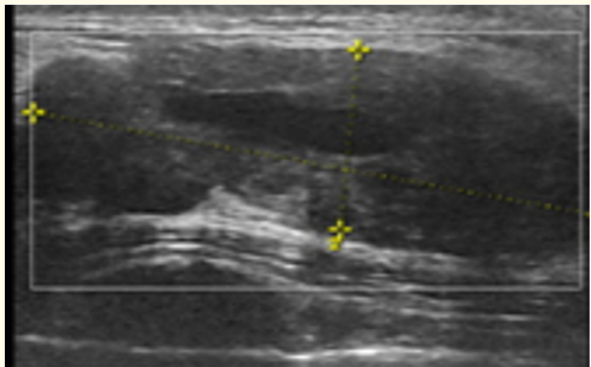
US showed a predominantly solid lesion with peripheral cystic changes (type III) and Doppler internal vascularity. US guided CNB proved to be IDC.
